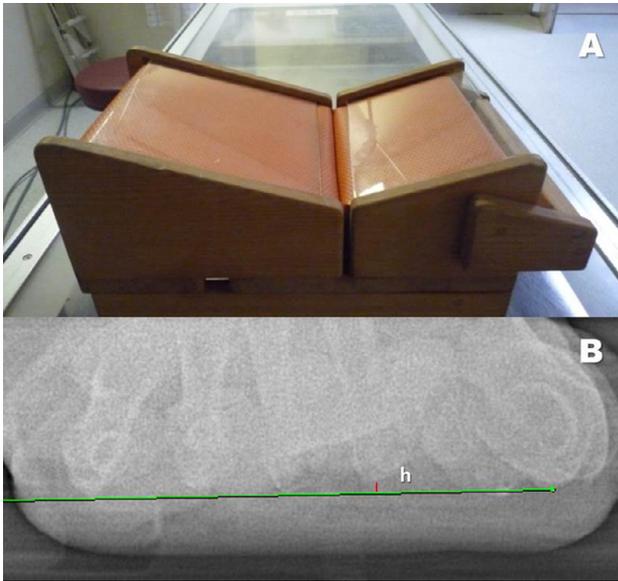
A specially designed standing apparatus was used for axial radiography of the forefoot (A). The relative height of the second metatarsal head was defined as the perpendicular height of the second metatarsal head from the baseline, drawn from the lowest point of the first metatarsal head to the lowest point of the fifth metatarsal head (B).
